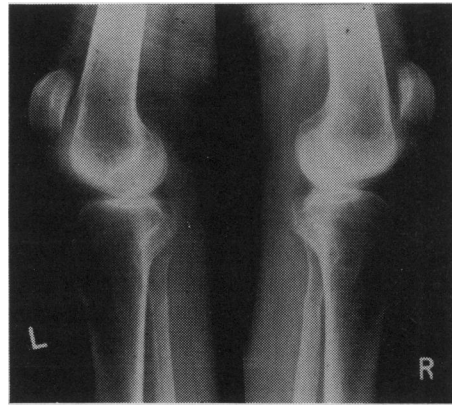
Lateral X-ray views of bilateral patellar tendon rupture. The high-riding patella, with the distance from the lower pole of the patella to the tibial tuberosity greater than the length of the patella is diagnostic.
